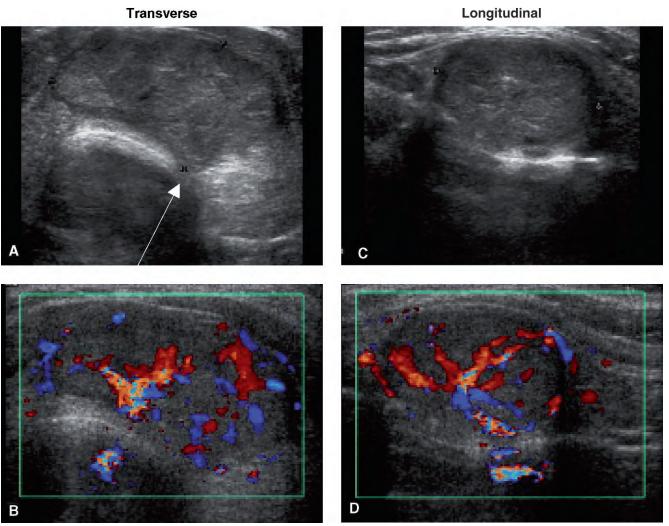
Ultrasound of follicular thyroid carcinoma in the isthmus. A, Transverse, 18 x 32 mm. Infiltration (*arrow*) through the capsule. B, Color Doppler, transverse. C, Longitudinal, sagittal diameter: 23 mm. D, Color Doppler, longitudinal
